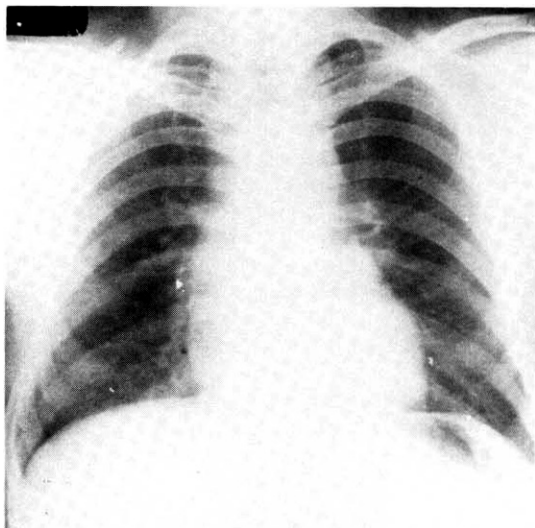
This chest X-ray shows slightly increased interstitial markings in both lower lung fields in one subject.
